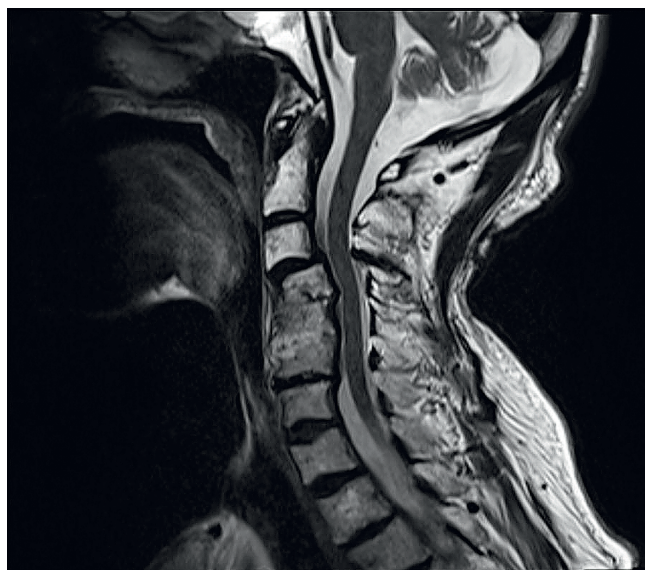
Preoperative T2 weighted cervical sagittal MRI image: Protrusion and grade 2 spondylolisthesis at C3–C4, obliteration of anterior cerebrospinal fluid column caused by osteophytes at C4–C5–C6, and loss of intervertebral disc height and degenerative fusion at C4–C5–C6.
